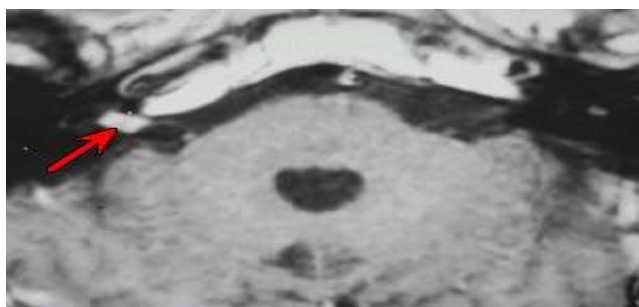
Enhancement of 8th cranial nerve on contrast T1 MRI due to vestibuloneuritis [9]
